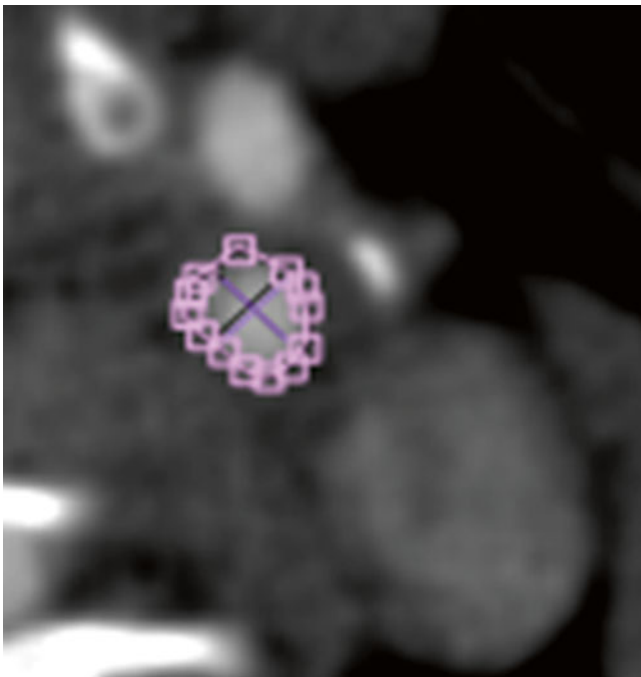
CTA is the only current angiographic method that allows such high-resolution images of contrast-filled vessels, plaque, and surrounding soft tissues
